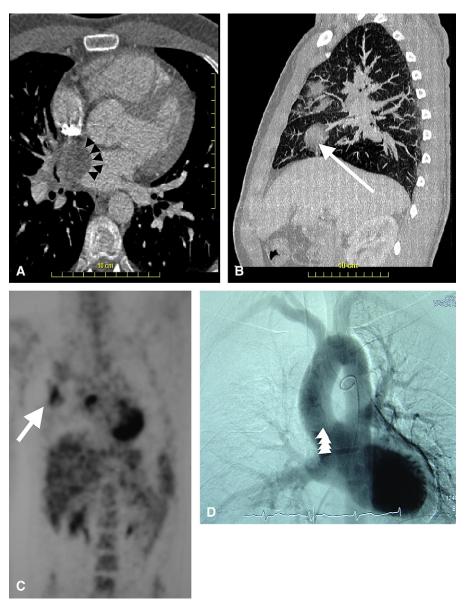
A, Preoperative chest computed tomography (CT) scan showing a solid mass in the left atrium with an occlusion of the right upper pulmonary vein (*small black arrows*). B, Preoperative chest CT demonstrating 2 masses in the upper (*black arrow*) and middle (*white arrow*) lobes. C, F-18 fluorodeox-yglucose positron emission CT showing an intense fixation of the tumor with a moderate fixation of the pulmonary opacities. D, Angiography showing complete occlusion of the right upper vein (*white arrows*).
